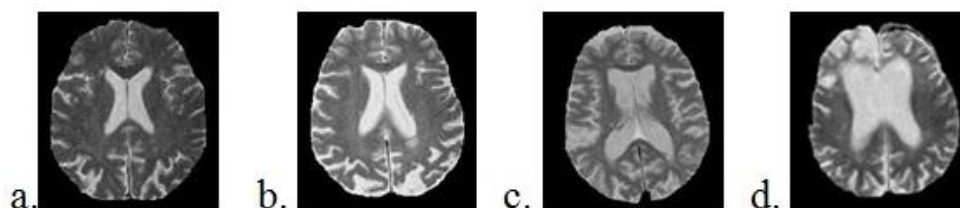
Samples of skull stripped brain MR images: (a) NC; (b) AD; (c) HD; (d) PD
